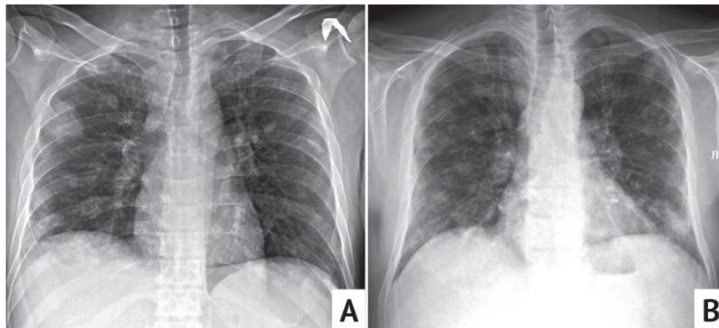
Posteroanterior chest X-ray images of patients with SPE. Nodulus and round shadows across all lung fields (A), subpleural heterogeneous shadows, nodules and increased pulmonary vascularity (B). Typical ring-shaped shadows (cavities) are not detected
